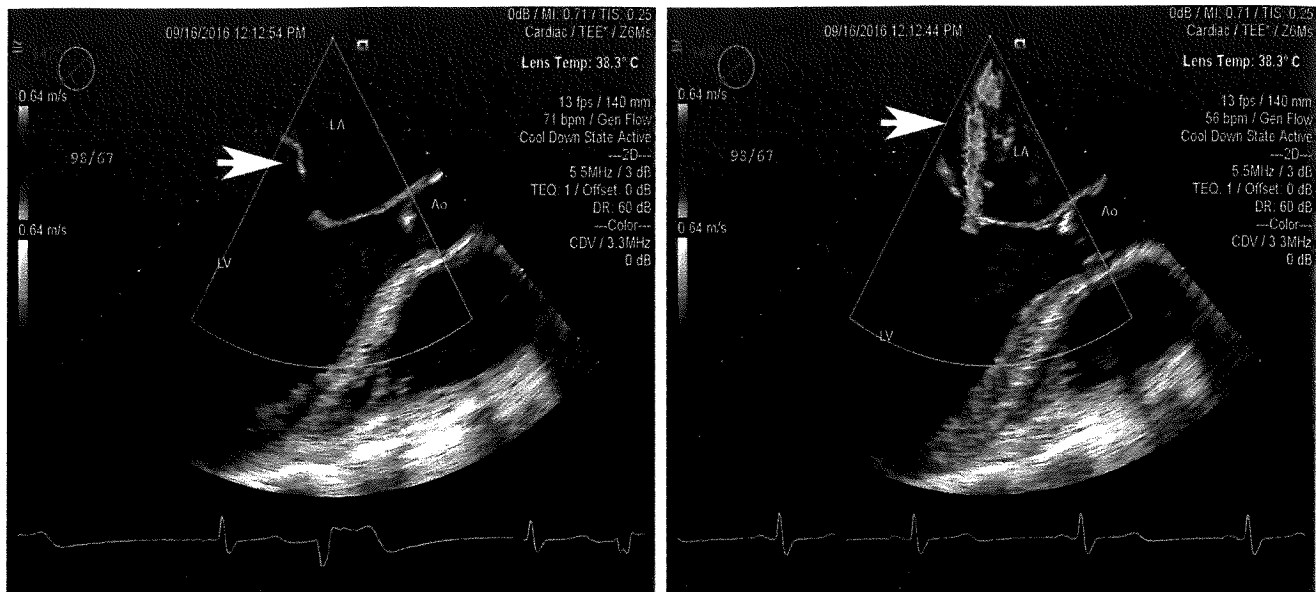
Echocardiograms demonstrating secondary mitral regurgitation in a patient with previous inferior myocardial infarction. Tethering of the posterior leaflet (arrow, left panel) is present due to the previous infarction and left ventricular remodeling. Mitral regurgitation (arrow, right panel) is evident on color flow imaging. Ao = ascending aorta; LA = left atrium; LV = left ventricle.
